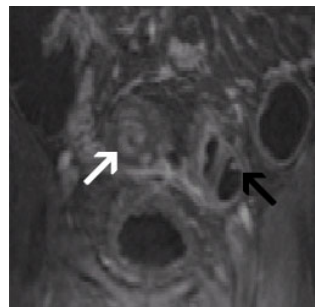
patient with incomplete endoscopy due to stenotic inflammatory lesion in sigmoid colon (white arrow). MRI revealed colonic polyp (black arrow) in a more proximal bowel segment, which could not be assessed by endoscopy.
